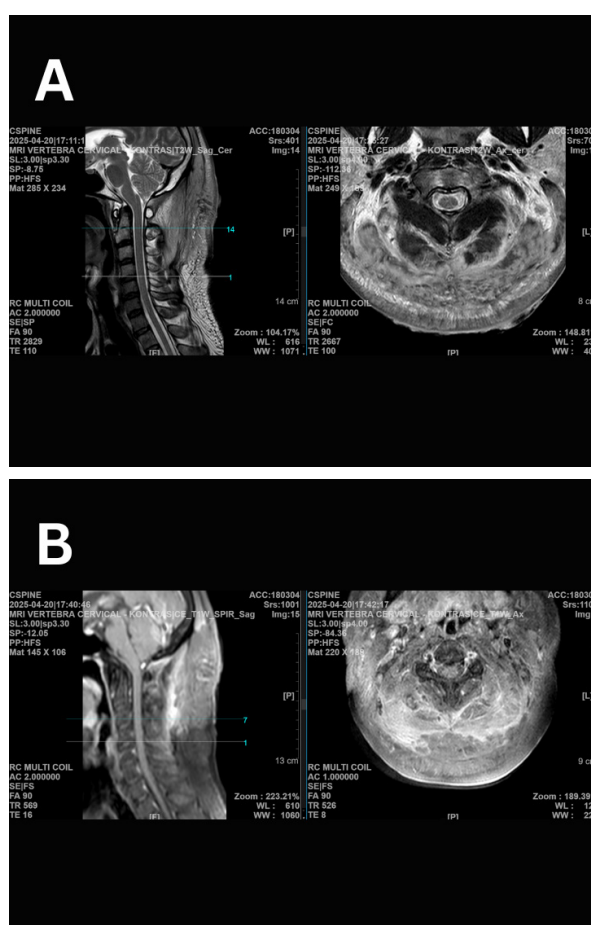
MRI of the occipital and cervical region, A: Sagittal and axial T_2 -weighted images, B: Sagittal and axial T_1 -weighted images
